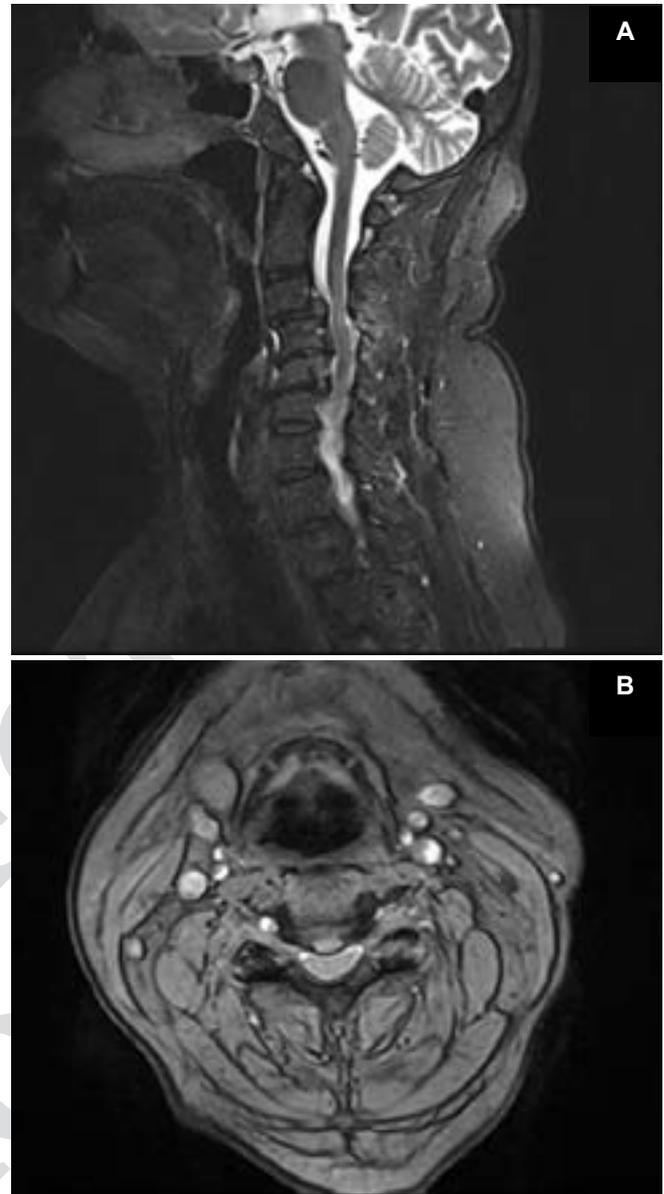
MRI of the cervical spine showed the spinal cord compression at C3–C4. At the level of C3–C5, the spinal cord signal intensity was slightly changed, as is the case with myelopathic changes visible myelopathy at C3–C4 which is more visible on figure B. Date of examination: November 28, 2018.
